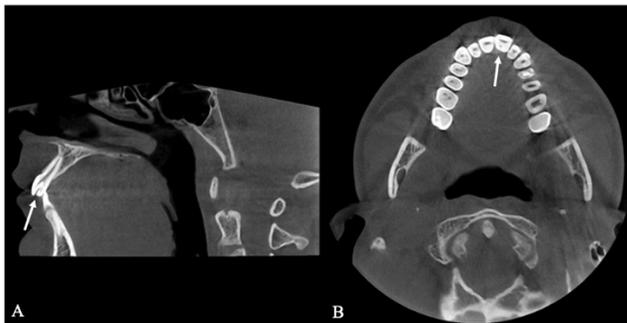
Sagittal (A) and axial (B) CBCT images of the taloned tooth showing the extension of the pulp.
